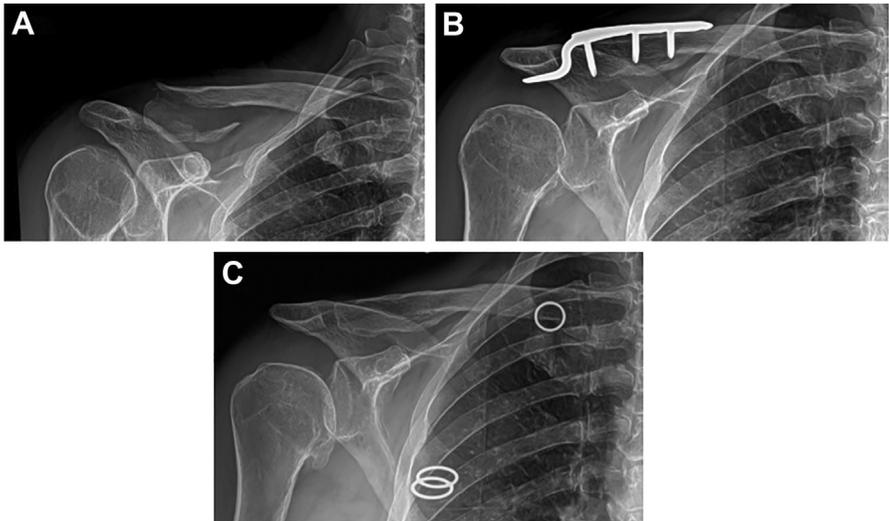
Hook plate case example (A) Radiograph of an acute displaced distal clavicle fracture with lateral comminution. (B) Hook plate at 3 months post-operatively with radiographic healing. (C) Hook plate removed after radiographic healing. (Images courtesy of Peter S. Verzeridis, MD).
